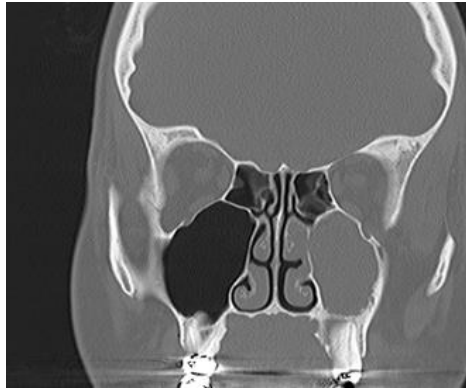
Coronal CT image of a patient with odontogenic sinusitis demonstrating complete opacification of the left maxillary sinuses. There is a periapical radiolucency of the left maxillary molar. (CT Image provided by Abdrabou A, Smith D, Fahrenhorst-Jones T, et al. Odontogenic sinusitis. Reference article, Radiopaedia.org. 2026, <https://doi.org/10.53347/rID-67428>)
